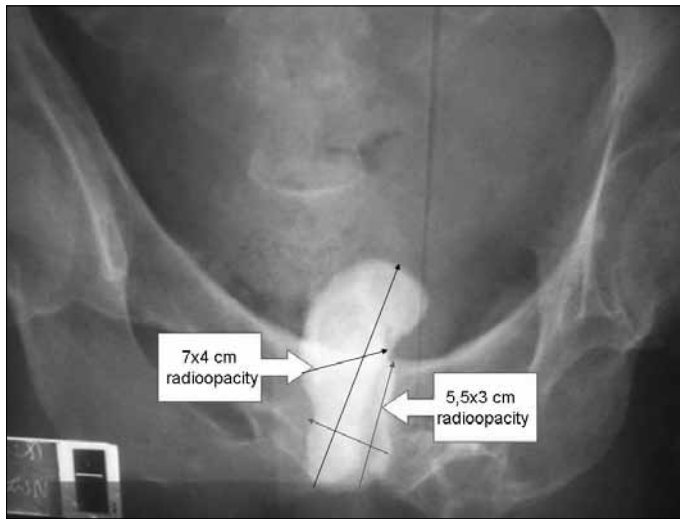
Pelvic radiography of the patient with two radioopacities measuring 7x4 cm and 5.5x3 cm behind the symphysis pubis
